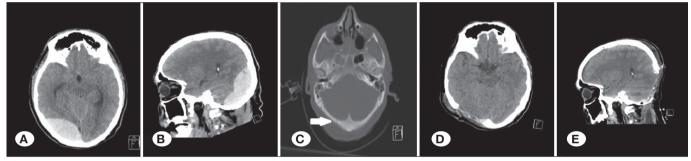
Preoperative CT of case 5 A) axial CT scan revealed epidural hematoma B) sagittal CT scan revealed supra-and infratentorial epidural hematoma C) linear skull fracture D) postoperative axial CT scan revealed occipital craniectomy E) postoperative sagittal CT scan revealed evacuation of epidural hematoma.
